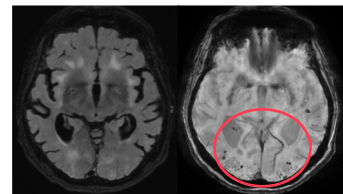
Follow-up axial FLAIR and SWAN
